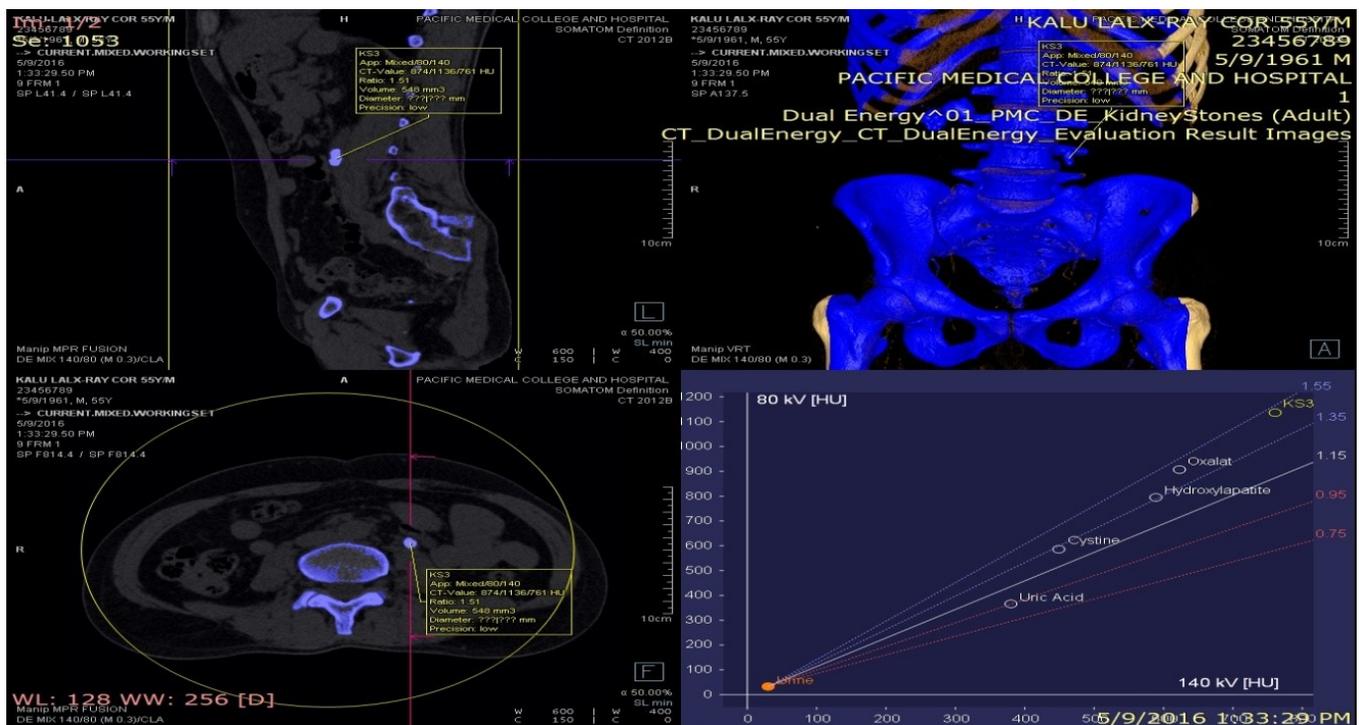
This is the case of 55 year old male having a staghorn calculus of 26mm size in the right renal pelvis with 6 small calculus in right inferior calyces and one calculus of 8mm sized in middle calyx of left kidney along with left upper ureteric calculus of 17mm size and resultant left hydronephrosis. The ureteric calculus shown in three views is automatically painted blue by software as its CT density lies in upper part of graph (in graph the circle of calculus KS3 showing density of around 1100 and average attenuation ratio 1.5, lying upper most part of graph). These software findings are suggestive of calcium oxalate calculus.
